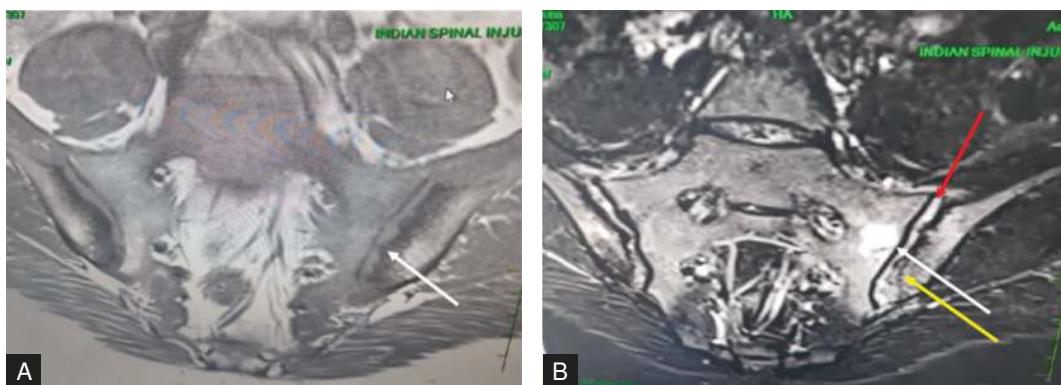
(A) MRI in a patient with axial spondyloarthritis. T1-weighted image reveals iso- to hypodense signal in the subarticular region of both the sacroiliac joints; white arrow shows subarticular erosions. (Courtesy: Dr Anita Agarwal, Dr Niti Bhatwal, and Dr Shriram Garg, ISIC, New Delhi.) (B) MRI in a patient with axial spondyloarthritis with active sacroiliitis. T2 fat suppressed image. Red arrow shows effusion in sacroiliac joint, white arrow shows bone marrow oedema, and yellow arrow shows erosions with minimal oedema. (Courtesy: Dr Anita Agarwal, Dr Niti Bhatwal, and Dr Shriram Garg, ISIC, New Delhi.)
